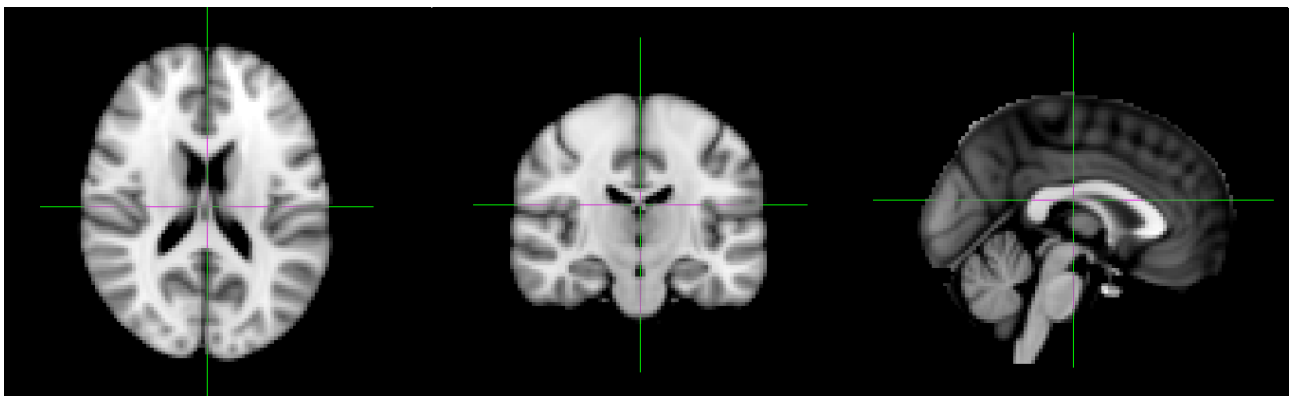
Dual regression z-maps on MRI T1 brain template. Pre vs. post placebo (map thresholded with p value $< 0,05$). In this contrast there is not an increase of connectivity statistically significant: results are under threshold and no area is colored.
